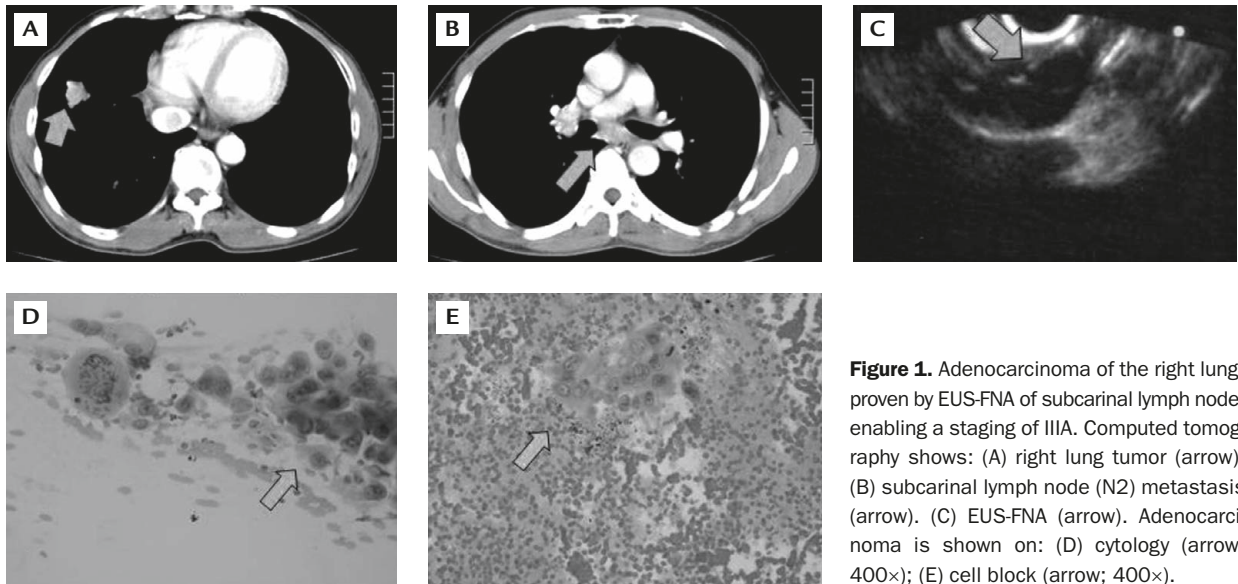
Adenocarcinoma of the right lung, proven by EUS-FNA of subcarinal lymph node, enabling a staging of IIIA. Computed tomography shows: (A) right lung tumor (arrow); (B) subcarinal lymph node (N2) metastasis (arrow). (C) EUS-FNA (arrow). Adenocarcinoma is shown on: (D) cytology (arrow; 400 \times); (E) cell block (arrow; 400 \times).
